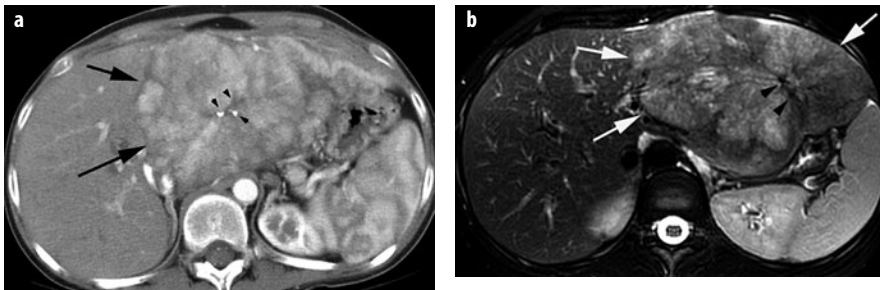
a, b. Fibrolamellar HCC. a CT during the arterial phase shows typical heterogeneously enhancing mass in left lobe (*arrows*), with low-attenuation central fibrous scar with calcifications (*arrowheads*). b T2-weighted MRI shows large, left-lobe mass (*arrows*) with heterogeneous appearance and mildly to moderately increased signal intensity. Fibrous central scar is of very low signal intensity (*arrowheads*)
